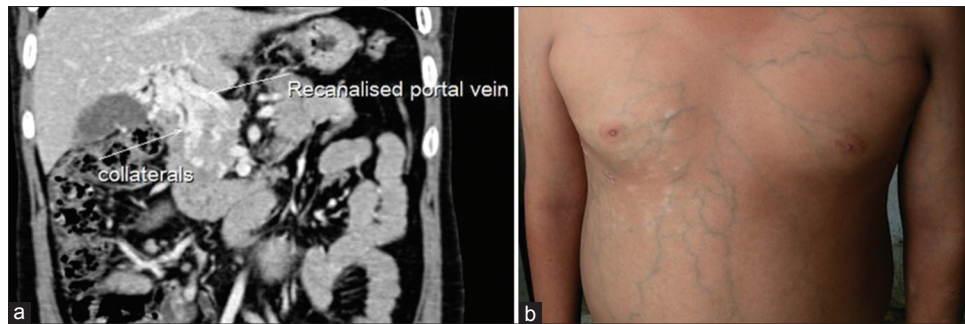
(a) Follow-up computed tomography angiography after 3 months of event showing contrast-filled recanalized portal vein with multiple contrast-filled collaterals and (b) clinical photograph 1 year later showing engorged vertical vein on the abdomen and chest
